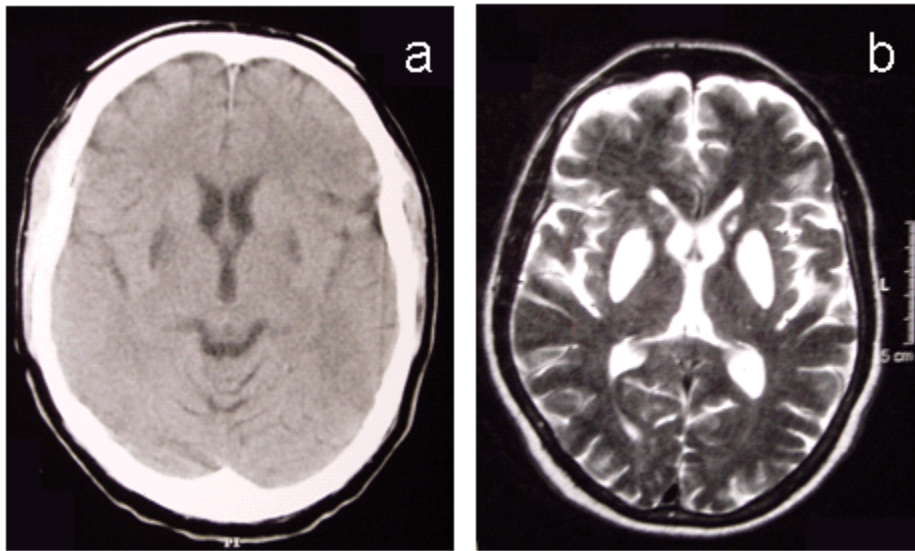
a. Non-contrast brain CT showing symmetric low signal in the putamina
